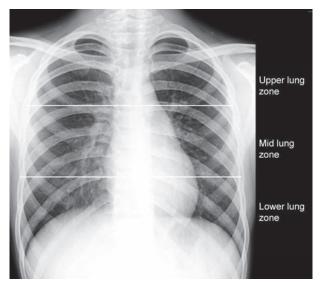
Chest X-ray PA view shows lung zones
